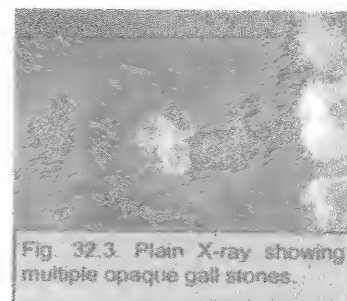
Plain X-ray showing multiple opaque gall stones.
